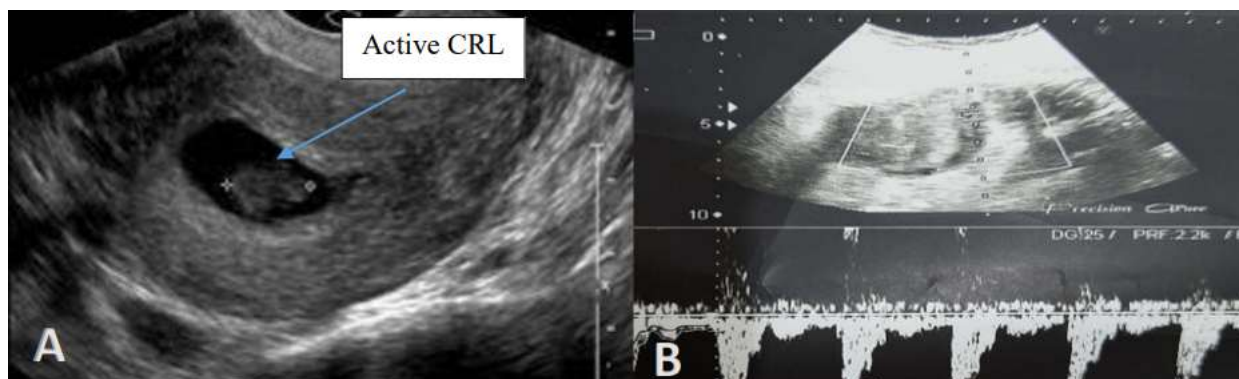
A 35 years old female patient presenting with 45 days of amenorrhea. (a) A transvaginal longitudinal greyscale image shows an enlarged uterus containing an active CRL (appointed by an arrow) corresponding to a gestational age of 7 weeks. (b) Transvaginal Doppler image shows left uterine artery confirmed by color Doppler and power Doppler shows RI=0.54 and PI=2.37.
